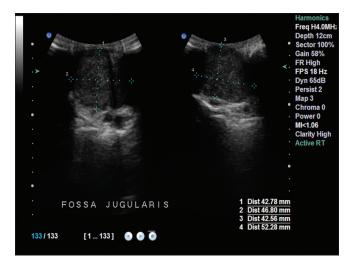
Ultrasound examination revealing a formation in the jugular fossa sized 43 mm  $\times$  47 mm  $\times$  52 mm
